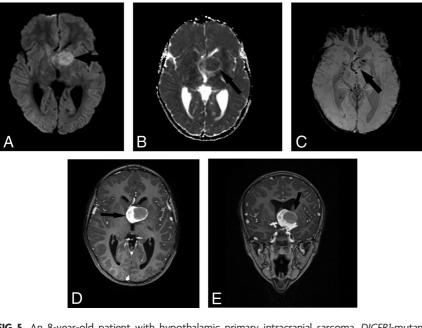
An 8-year-old patient with hypothalamic primary intracranial sarcoma, *DICERI*-mutant. *A and B*, DWI and ADC map demonstrating diffusion restriction of the left hypothalamic lesion nonenhancing component. This is partially explained by the blood products noted on SWI and the cellularity of the nonenhancing component. *C*, SWI sequence demonstrates a loss of signal within the lesion that is suggestive of blood products (*arrow*). *D*, Axial postcontrast TI MPRAGE demonstrates a mixed enhancing and nonenhancing lesion with homogeneous enhancement of the solid component (*arrow*). *E*, Coronal postcontrast TI MPRAGE demonstrates a mixed enhancing lesion with homogeneous enhancement of the solid component (*arrow*).
